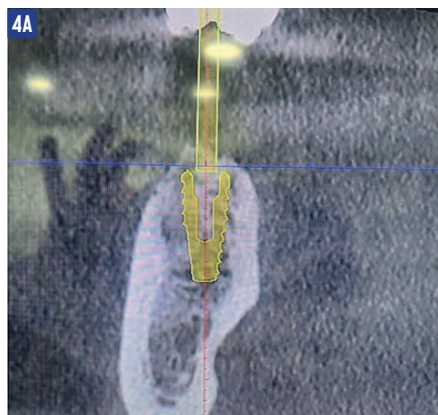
Pre-extraction radiograph
